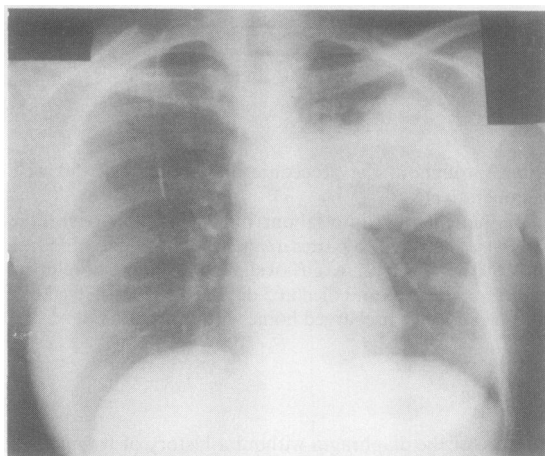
Chest radiograph showing an opaque mass lesion in the left lung. The shadow is essentially solid, without apparent cavitation. The surrounding lung fields are relatively clear.
